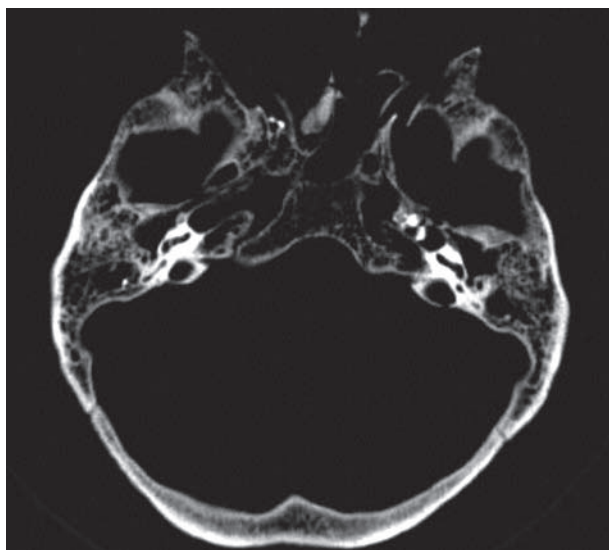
CT images shown areas of structural thickening compact dense and homogeneous, with net margins and peripheral rim radiolucent, localized in the right sphenoid sinus, ethmoid cells in the rear of the left and the apex of the petrous left.
